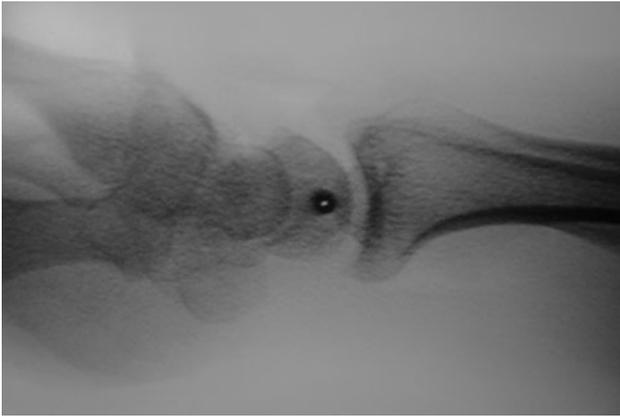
Lateral radiograph of the wrist. Immediate postoperative image shows reduction in scapholunate and radiolunate angles.
